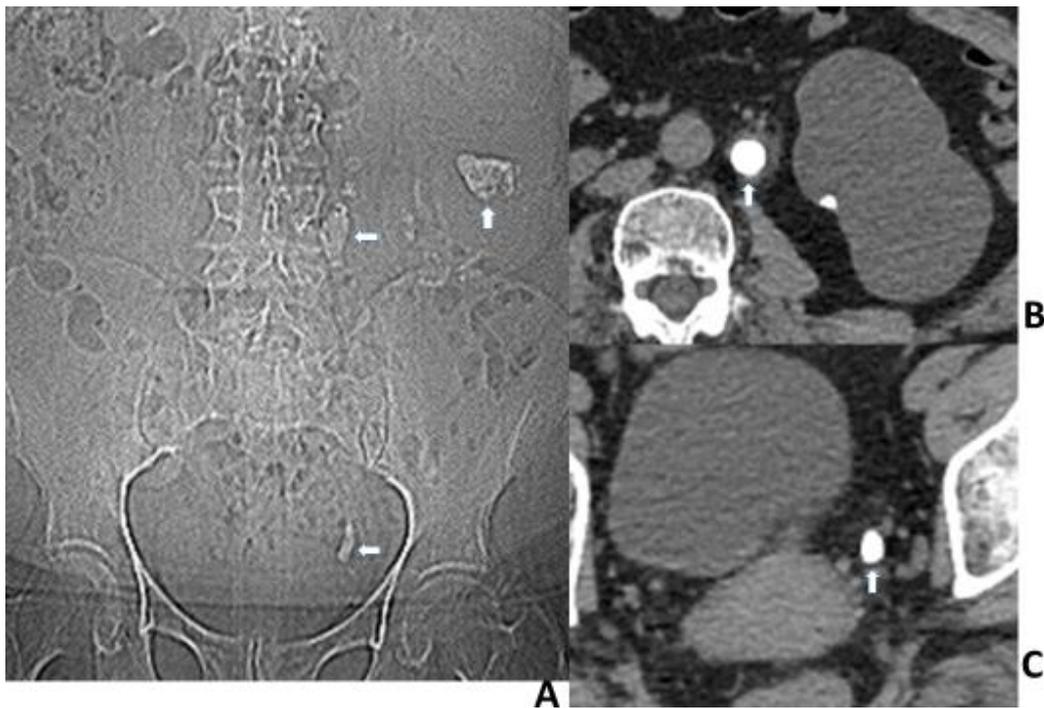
80-year-old woman with left renal and ureteral stones. A CT scout radiograph shows multiple left renal stones (vertical arrow), two left ureteral stones (horizontal arrows). B, Axial CT scan shows proximal left ureteral stone (arrow) measuring 12 mm. C, axial CT scan shows distal left ureteral stone (arrow) measuring 11 mm.
